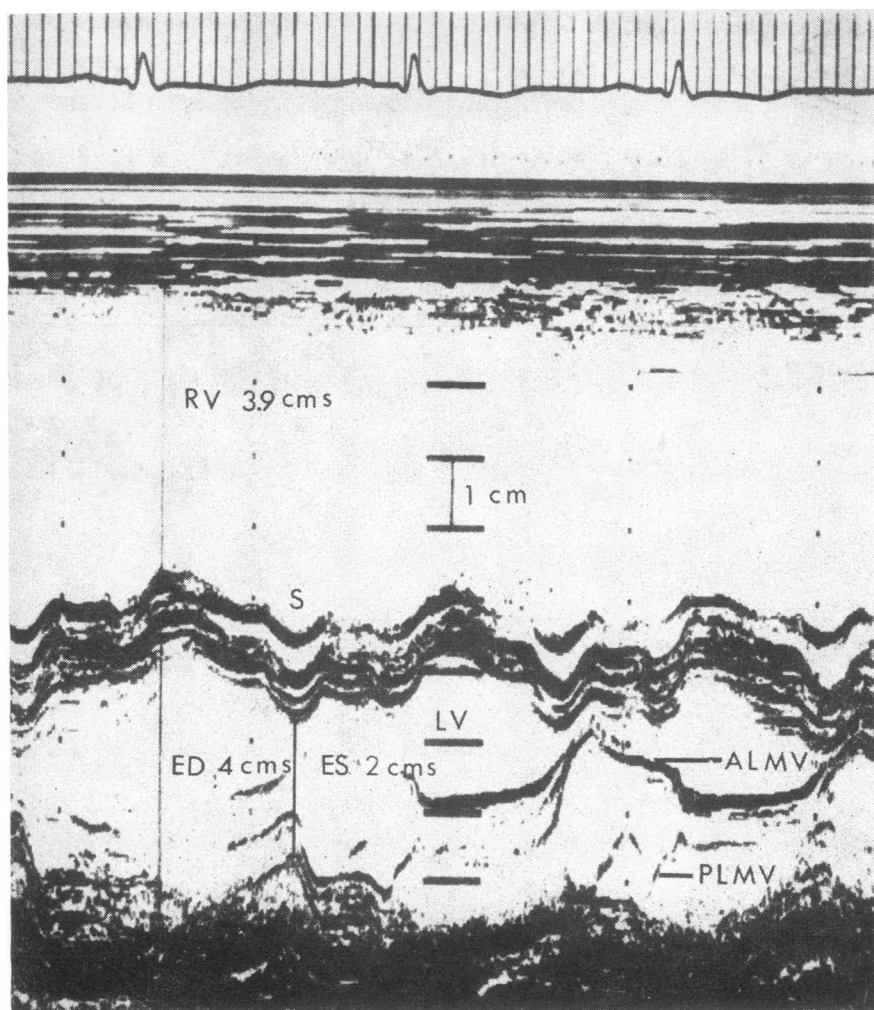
Echocardiogram showing enlarged right ventricle (RV) with normal motion of non-thickened septum (S). LV, left ventricle; ED, end-diastolic diameter of the left ventricle; ES, end-systolic diameter of the left ventricle; ALMV, anterior leaflet of the mitral valve; and PLMV, posterior leaflet of the mitral valve.
